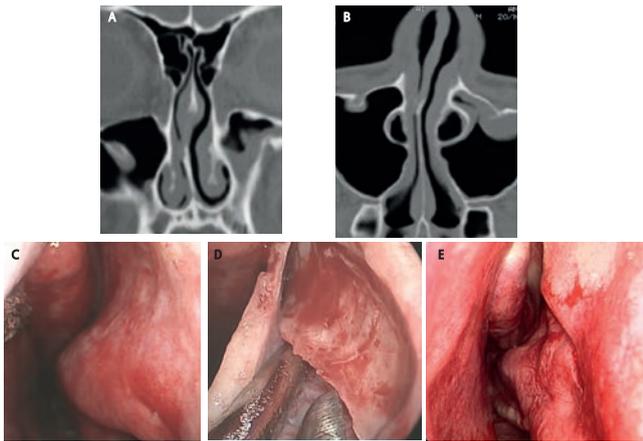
Pre-operative coronal (A) and axial (B) CT showing impingement of the left lateral nasal wall on the airway as well as septal deviation to the right and pre (C), peri- (D) and post- (E) operative view after piriform-turbinoplasty.
